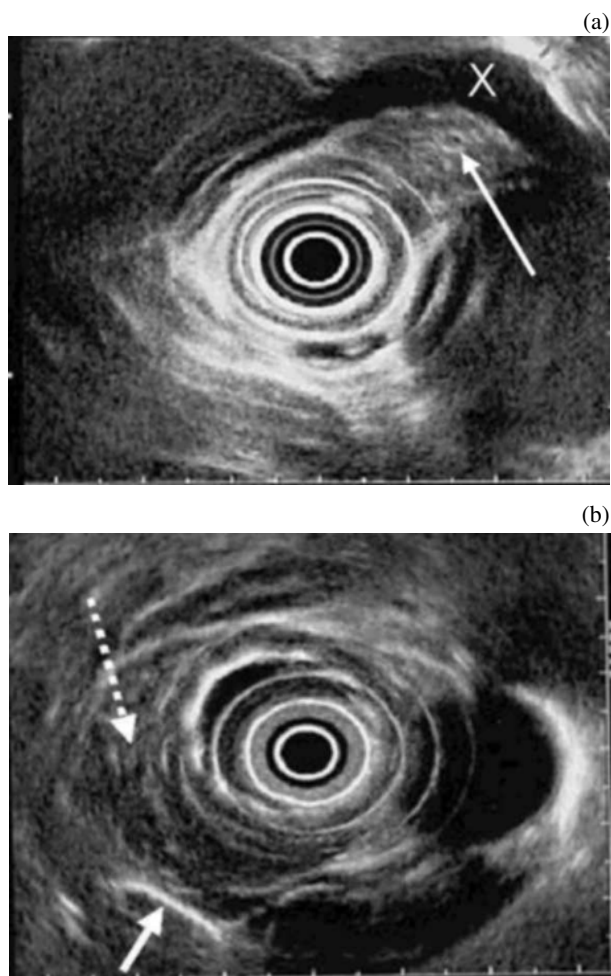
Endoscopic ultrasound of patients with oesophageal cancer with mediastinal invasion. (a) Oesophageal tumour (T4): the tumour (white arrow) is adherent to the left pulmonary vein (white cross) with loss of the intervening plane. (b) Oesophageal tumour (T4): the tumour (broken white arrow) has breached the pleura (white arrow) to invade the right lung.
